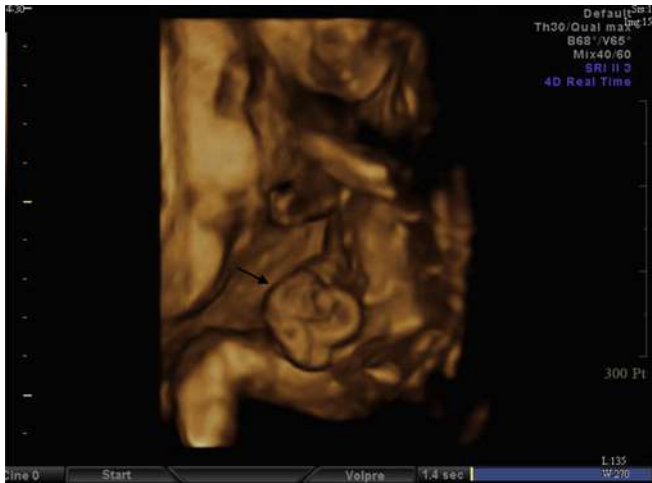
Prenatal 3D ultrasound (surface rendering mode) of gastroschisis at 20 weeks of gestation (the same case as Fig. 1) with viscera protrusion (arrow).
